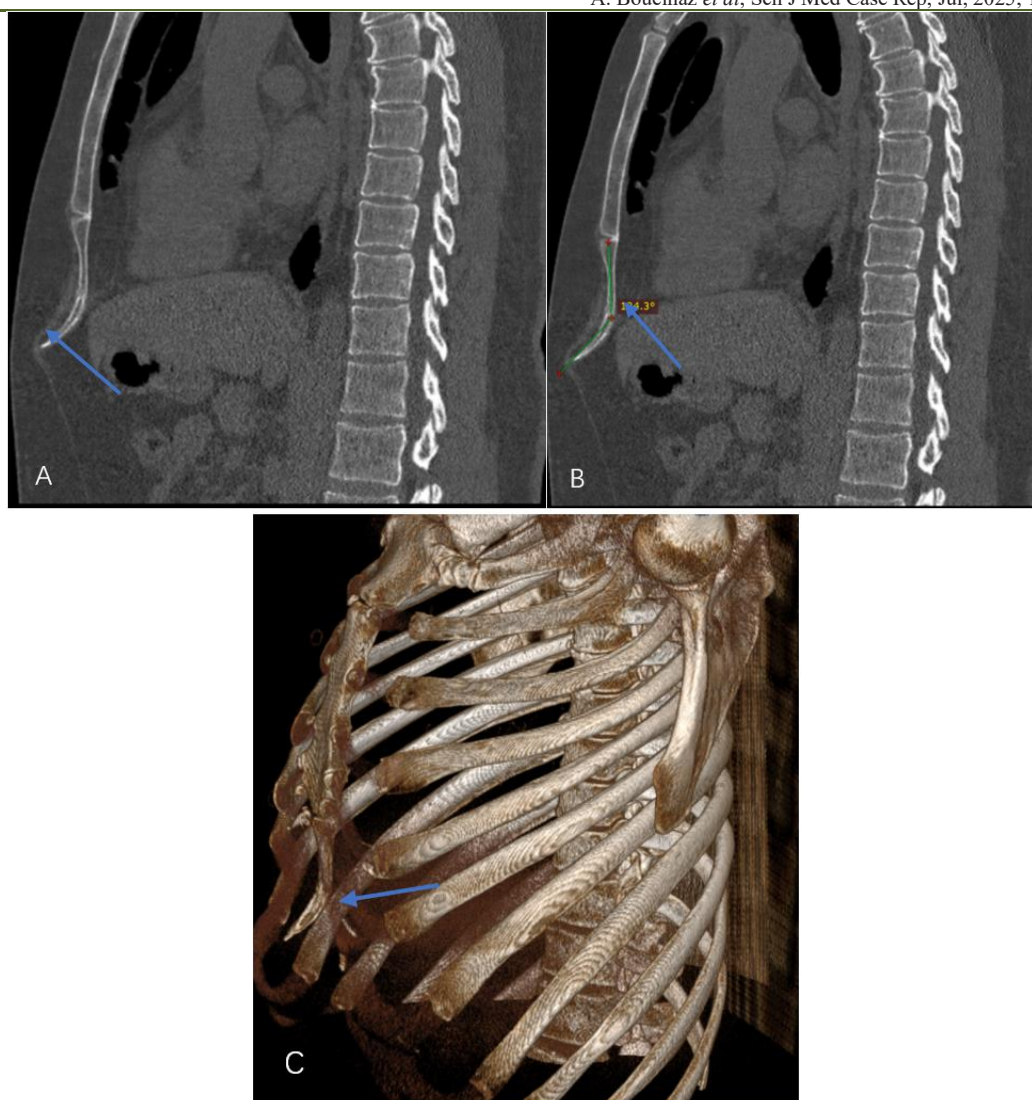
Sagittal bone CT images (A and B) and 3D reconstruction (C) showing a prominent xiphoid process with a xiphosternal angle of 134.3°. (Blue arrow)
